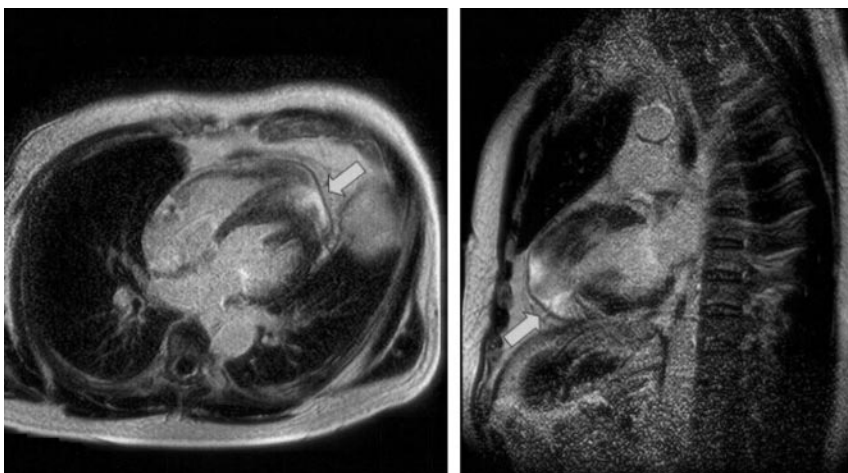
Contrast-enhanced image obtained by MRI of 4-chamber view (left) and 2-chamber view (right) showed prominent delayed hyperenhancement localized at subepicardial area of left ventricular apex.
